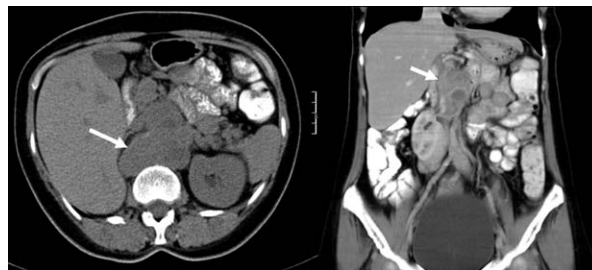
The arrows show retroperitoneal aortacaval mass in abdominal CT (transverse and coronal images)
